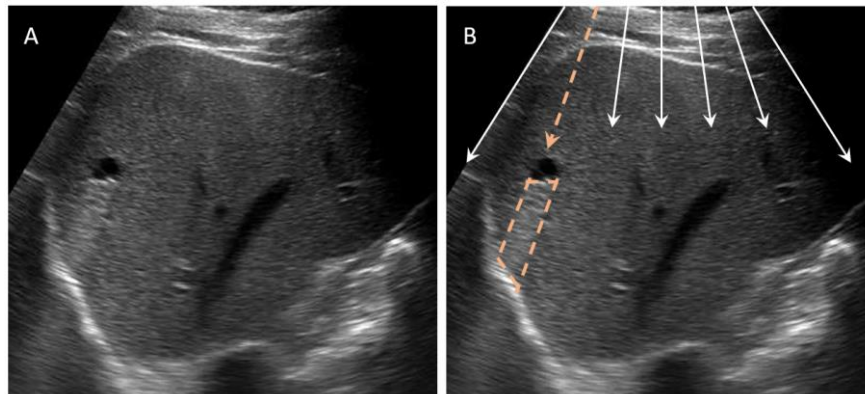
(A) An ultrasound image with a hepatic cyst (B) The arrows present the alignment of ultrasound beams and the dashed arrow point to the cyst (black oval) and its artefact in the dashed line area align with the ultrasound beam.
